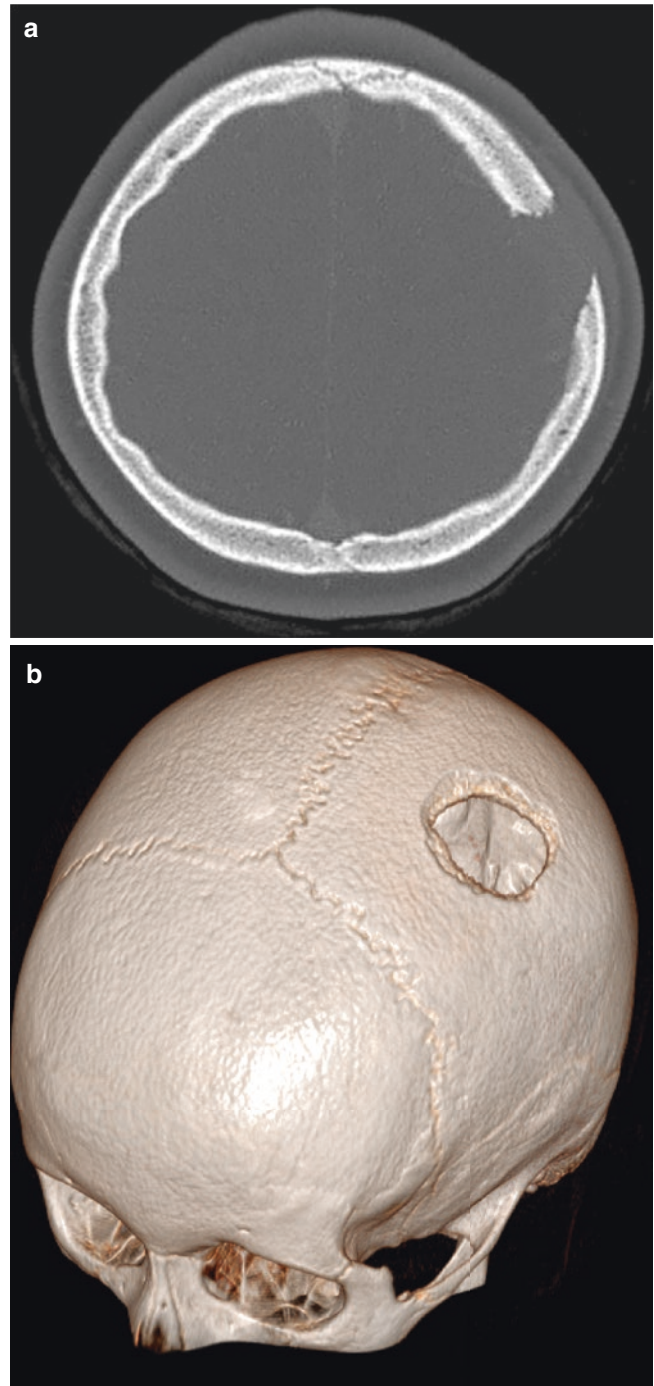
LCH. (a) Axial CT image demonstrates a lytic lesion in the left parietal bone. (b) The greater destruction of the inner than the outer table results in the bevelled appearance of the lesion as seen on the 3D reformatted image
